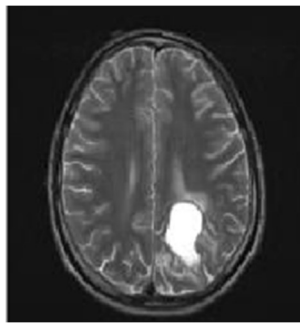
MRI input of Brain
